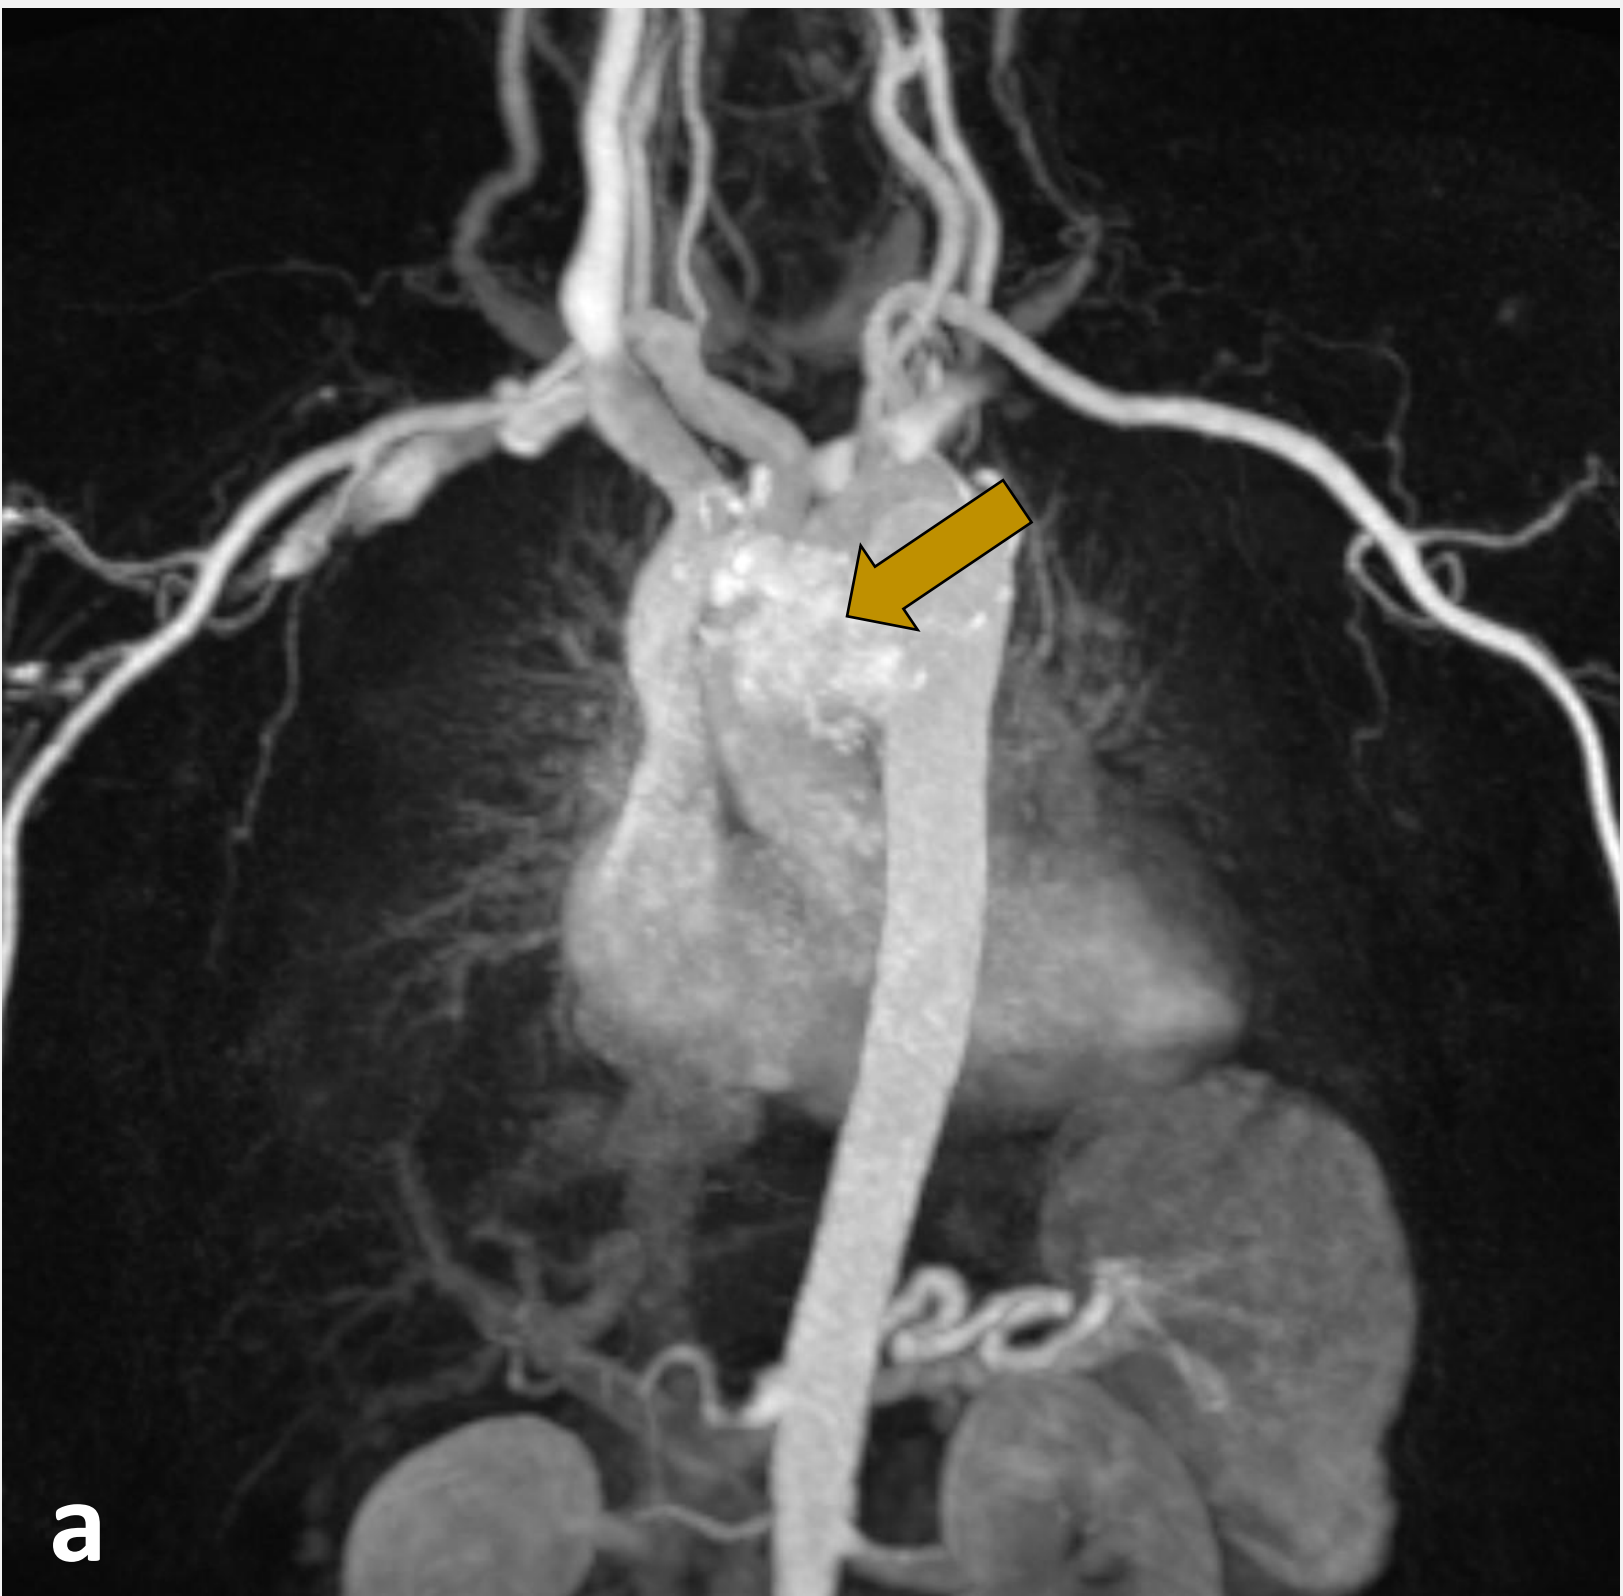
(a) time-resolved MR angiography (TWIST) demonstrating marked tumor hypervascularity, (b) axial venous-phase contrast-enhanced CT image.
